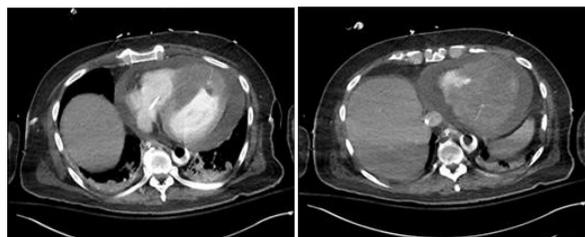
CT chest showing large pericardial effusion, massive left ventricle filling defect, and anterior bulging of the left ventricle along right ventricular apex.
